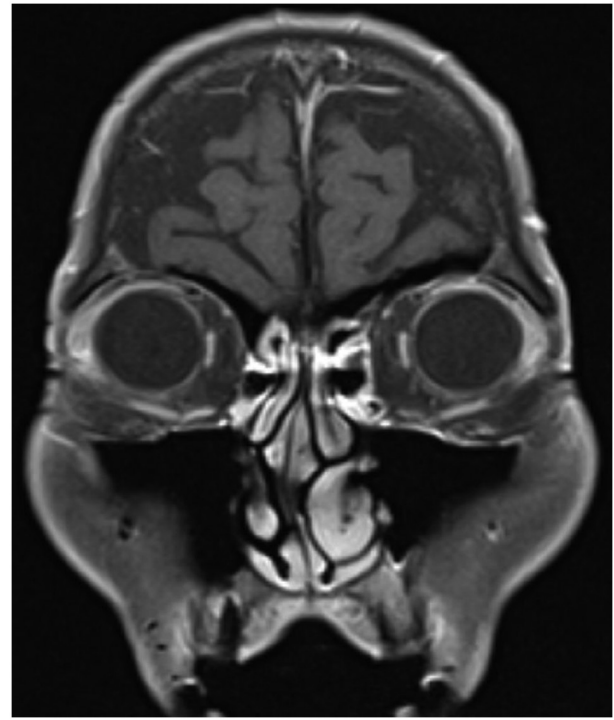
Image acquired from magnetic resonance imaging performed 1 year after stereotactic radiotherapy revealing metastatic choroidal tumor becoming obscured.
